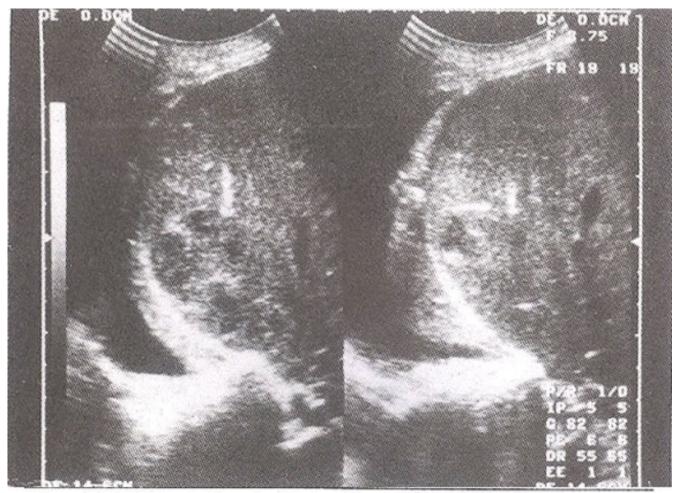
(b). Right subpulmonic effusion. Ultrasound examination demonstrating the right pleural effusion with associated partial atelectasis.
